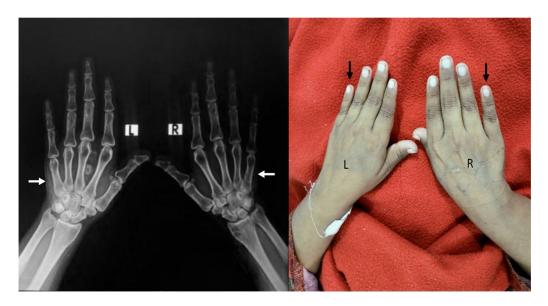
Radiograph and picture showing short fifth metacarpal bones.
